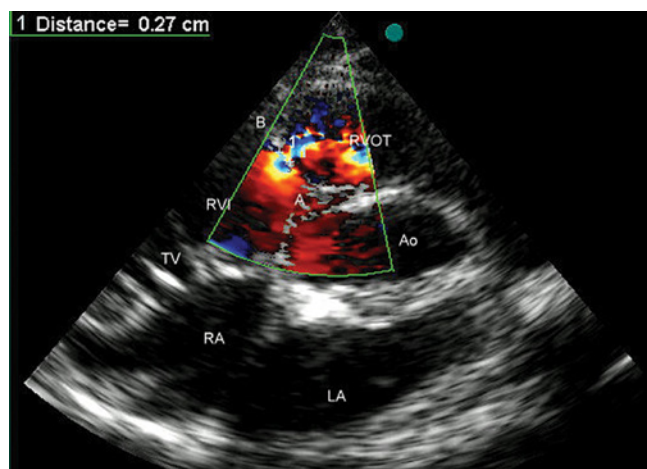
Visualizations with color Doppler of the flow through the diaphragm dividing the RV; An orifice of only 3–4mm diameter is visible. Designations as in Fig. 2
